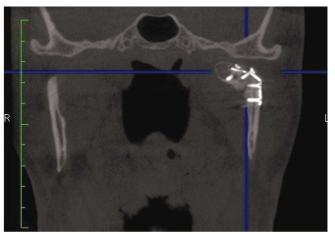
Preoperative view of temporomandibular joint (coronal computed tomogram), with a malunionn of left condile.
